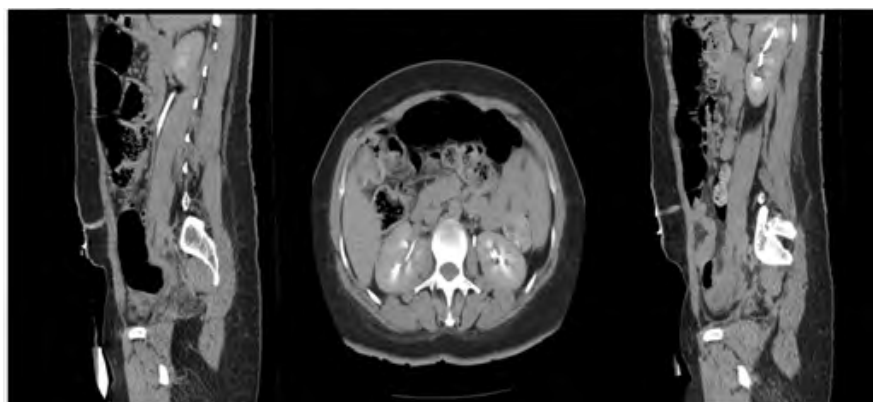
CT urogram 5 months after CD and cystectomy
